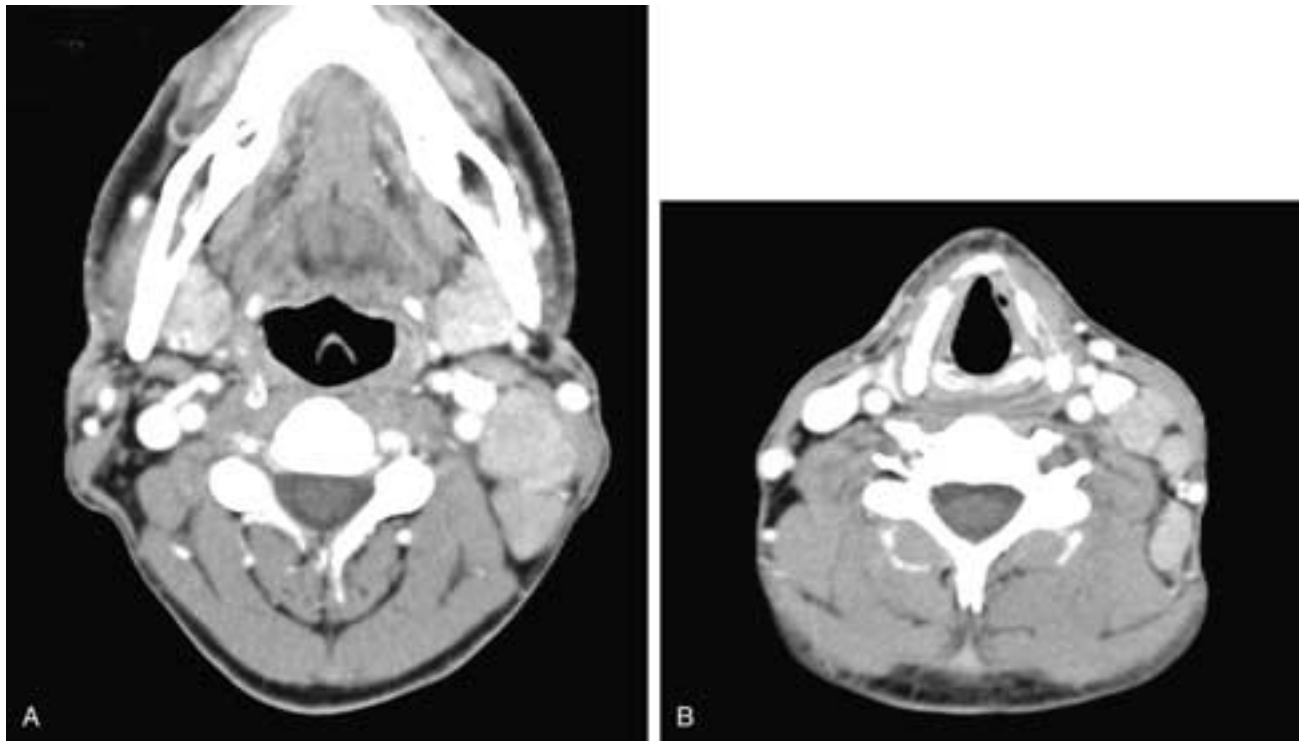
Cranial (A) and caudal (B) axial contrast-enhanced CT scans show multiple enlarged, enhancing, fairly homogeneous, well-delineated nodes in the left neck. Nodes are seen in levels II, III, and V. This patient had EBV infection.
